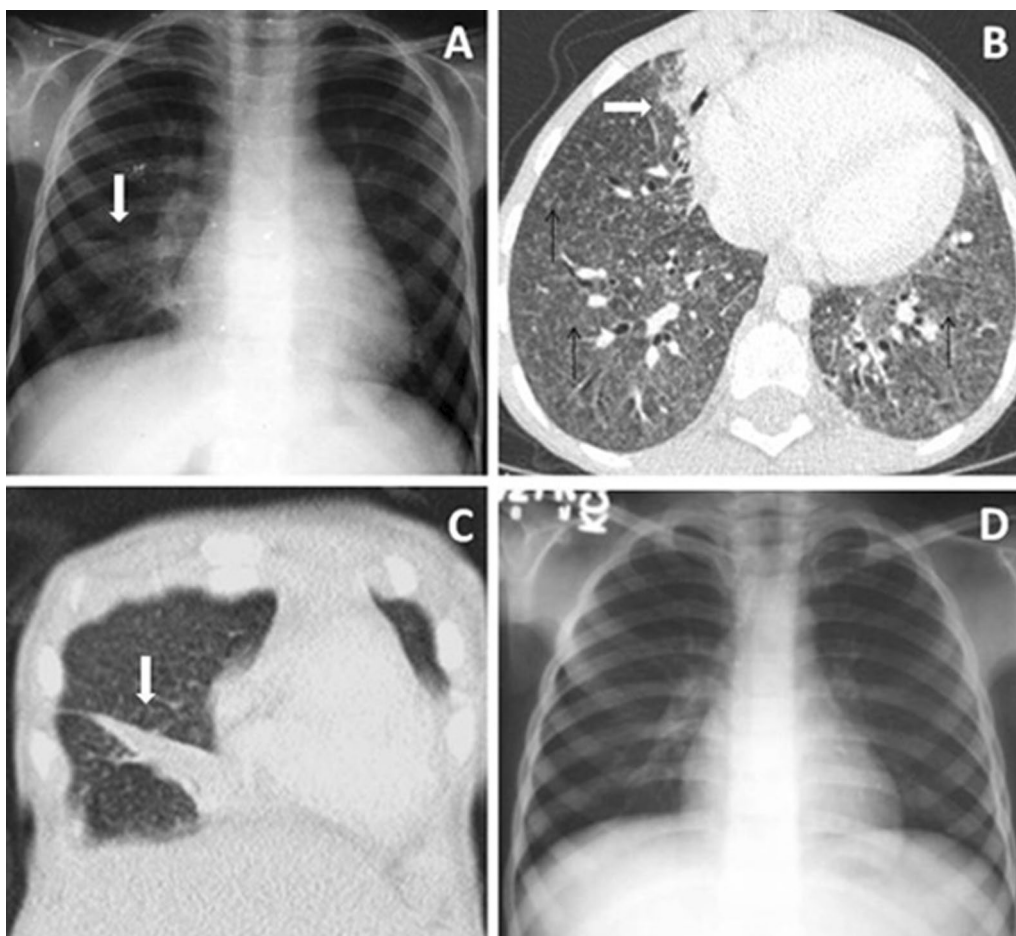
Bacterial Infection. CXR (PA view) in a 12-year-old HIV-positive child reveals inhomogeneous opacity in right para-cardiac region (arrow in A). CT chest (lung window) shows presence of consolidation (white arrow in B) in medial segment of RML, along with centrilobular nodules (black arrows in B) in bilateral lung fields on axial image, and collapse of anterior segment of RUL on sagittal image (arrow in C). Sputum could not isolate any microorganism. CD4 count was 400 cells/cu.mm. Patient was given antibacterial antibiotics and improved clinically & radiologically (D) over a period of 3 weeks
